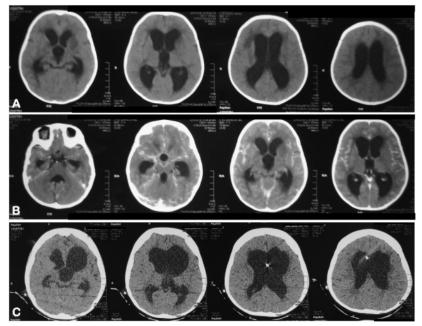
Head CT-Scan in 2015 with hydrocephalus, showing dilated temporal horn and ballooning of the lateral ventricle, and 3rd ventricle (A and B). Head CT-scan with contrast, depicting leptomeningeal enhancement, especially of the basal cranium (B). Head CT-Scan in 2020 (C), it appears lateral ventricles and the 3rd ventricles widened compared to previous head CT-Scan in 2015 (A and B).
